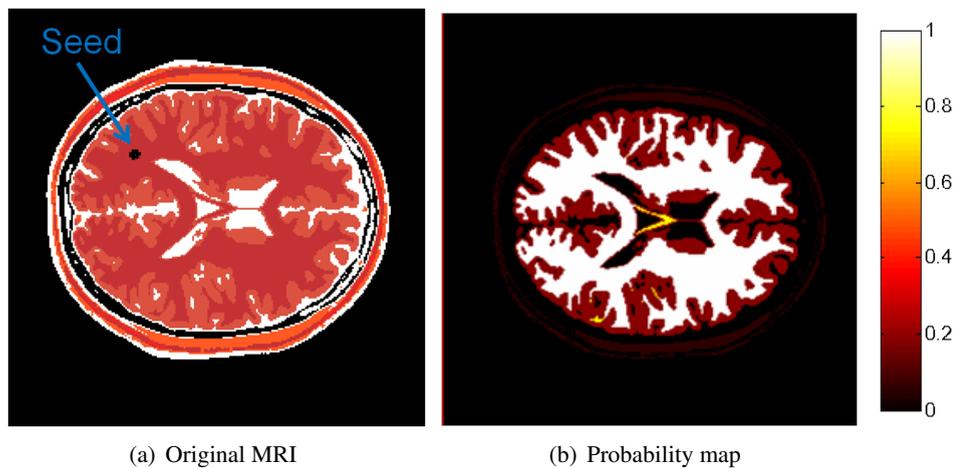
Probability map of white matter segmentation for original labeled MRI image by using only *RG*.
